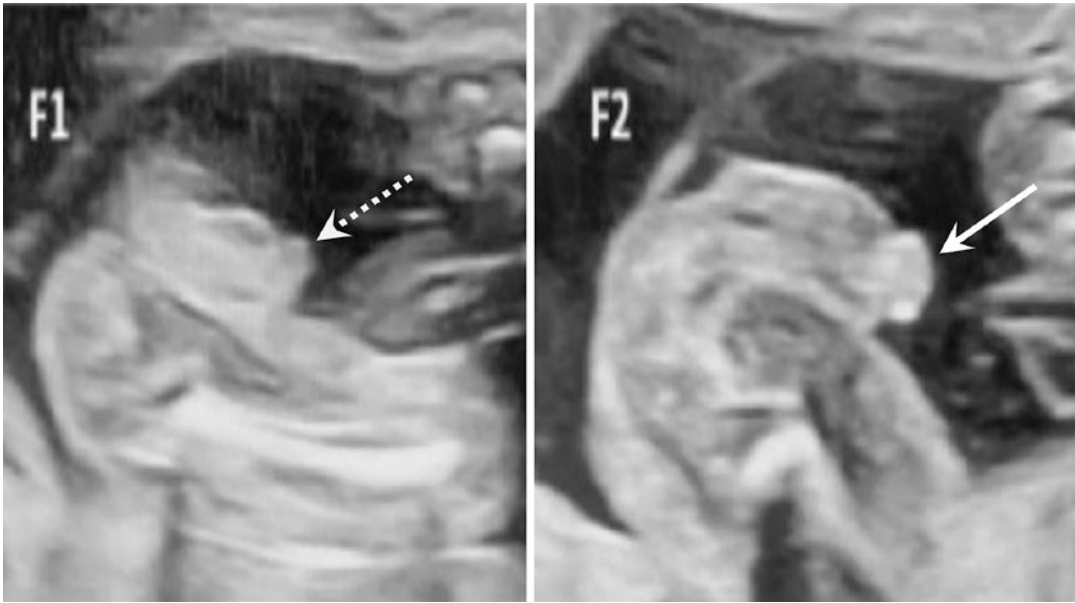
Fetal ultrasound showed that the F1 placenta was located in the posterior wall of the uterus, and the clitoris of the external genitalia was slightly hyperechoic
